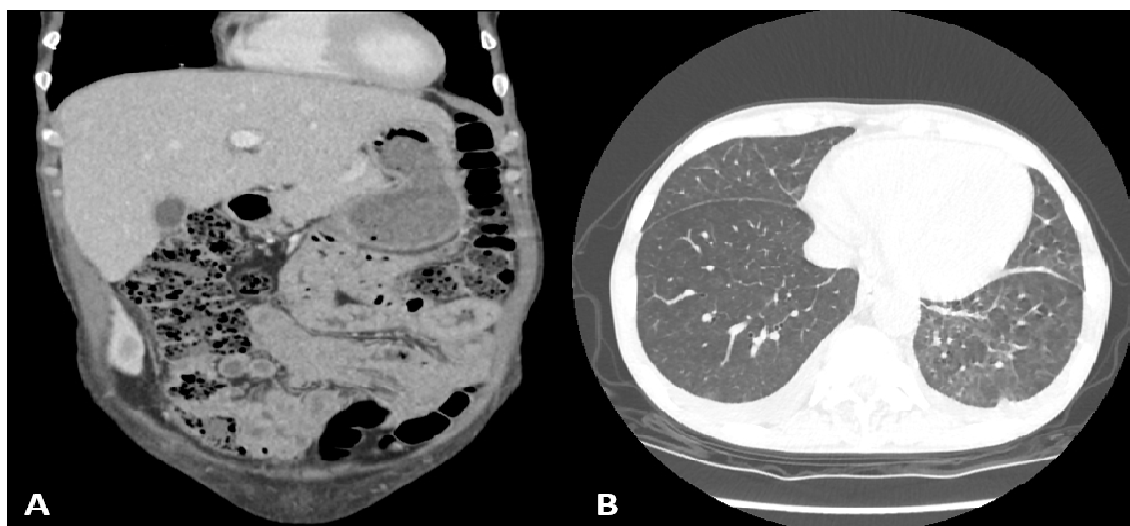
(A) Coronal CT abdomen image demonstrates a sub-stenosing parietal thickening of the cecum. (B) Axial CT chest image revealing reticulonodular infiltrates with tree-in-bud (branching).
